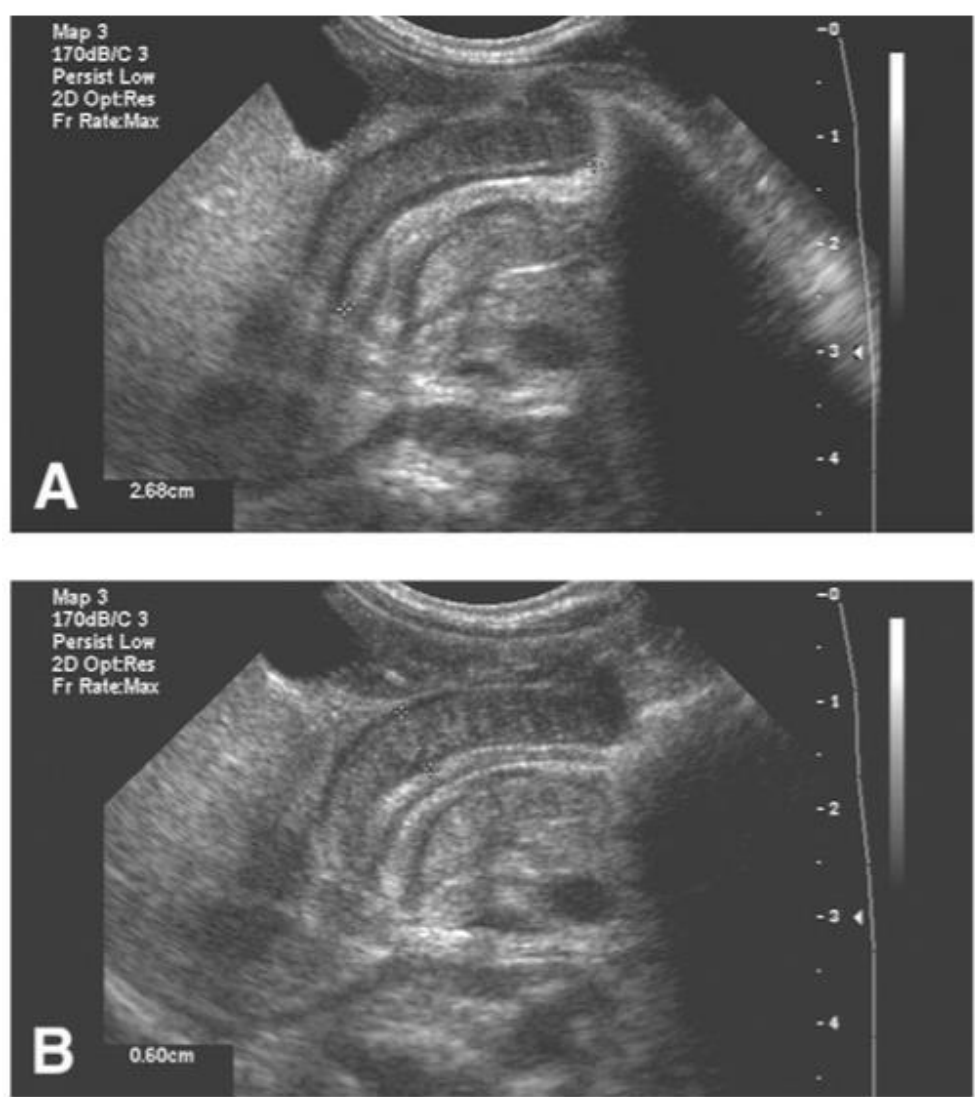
Ultrasound images of the hypertrophied pylorus in a 5-week-old infant (A) pyloric length measuring 26.8 mm and (B) pyloric muscle thickness measuring 6.0mm (*Seminars in Pediatric Surgery*)
